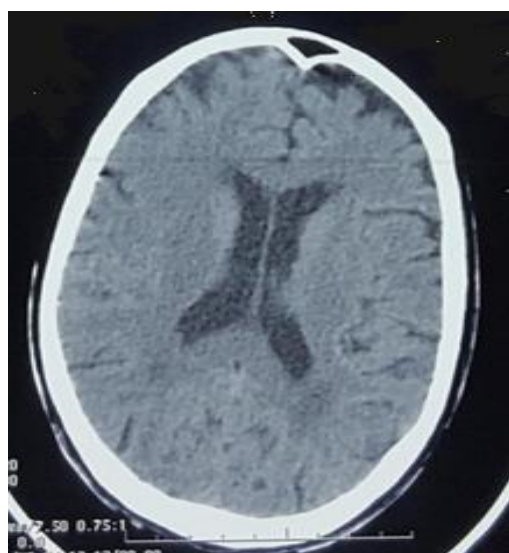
CT scan performed one hour after showing early signs of a right Sylvian stroke
